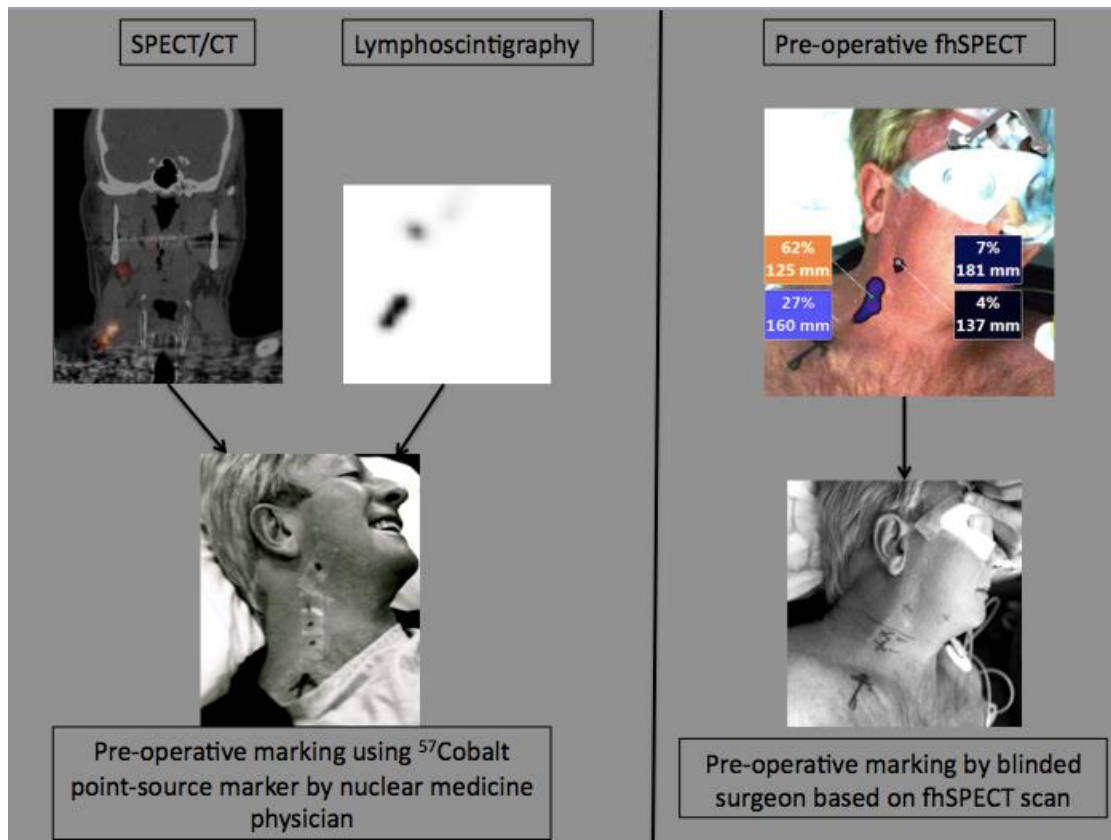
Sentinel node identification by SPECT/CT and lymphoscintigraphy versus fhSPECT. All modalities found three sentinel nodes. Neck markings by nuclear medicine (left) and surgeon (right) can be compared (Nb. anterior mark 'x' by surgeon denotes the tumour site, which is masked in the nuclear medicine scans)
